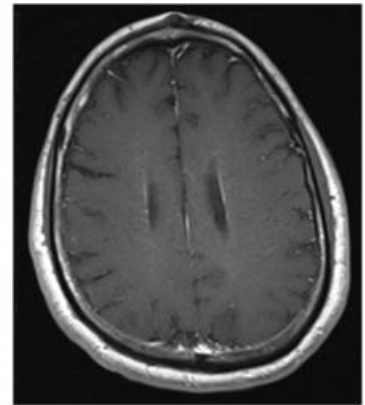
Five week follow up T1-weighted MRI brain with contrast demonstrates near-complete resolution of periventricular curvilinear enhancement.
